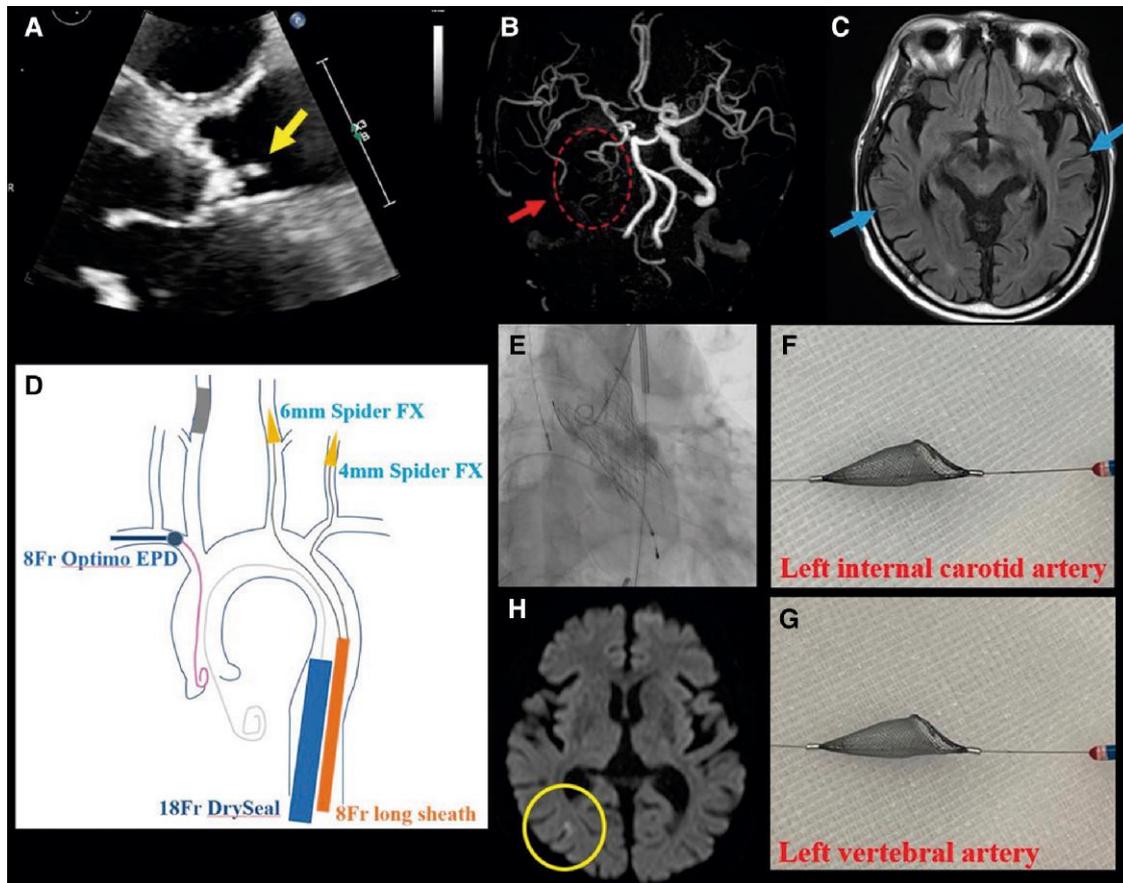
(A) Pre-operative transthoracic echocardiography showing a 7.5 mm high echoic mobile mass (arrow) attached to the calcification of the aortic valve on the non-coronary cusp. Pre-operative brain magnetic resonance angiography and magnetic resonance imaging showing (B) the occlusion of the right internal carotid artery (arrow) and (C) the intra-arterial signal (arrow) on fluid attenuated inversion recovery images. (D) Cerebral embolic protection strategy during transcatheter aortic valve replacement. Spider FX 6 mm and Spider FX 4 mm in the left internal carotid and the left vertebral arteries, respectively. An 8 Fr OPTIMO embolic protection device in the right subclavian artery. (E) Final angiogram during transcatheter aortic valve replacement. (F and G) No macroscopic materials in all filters after transcatheter aortic valve replacement. (H) Post-operative diffusion-weighted magnetic resonance imaging showing several small ischaemic lesions (circle). EPD, embolic protection device.
